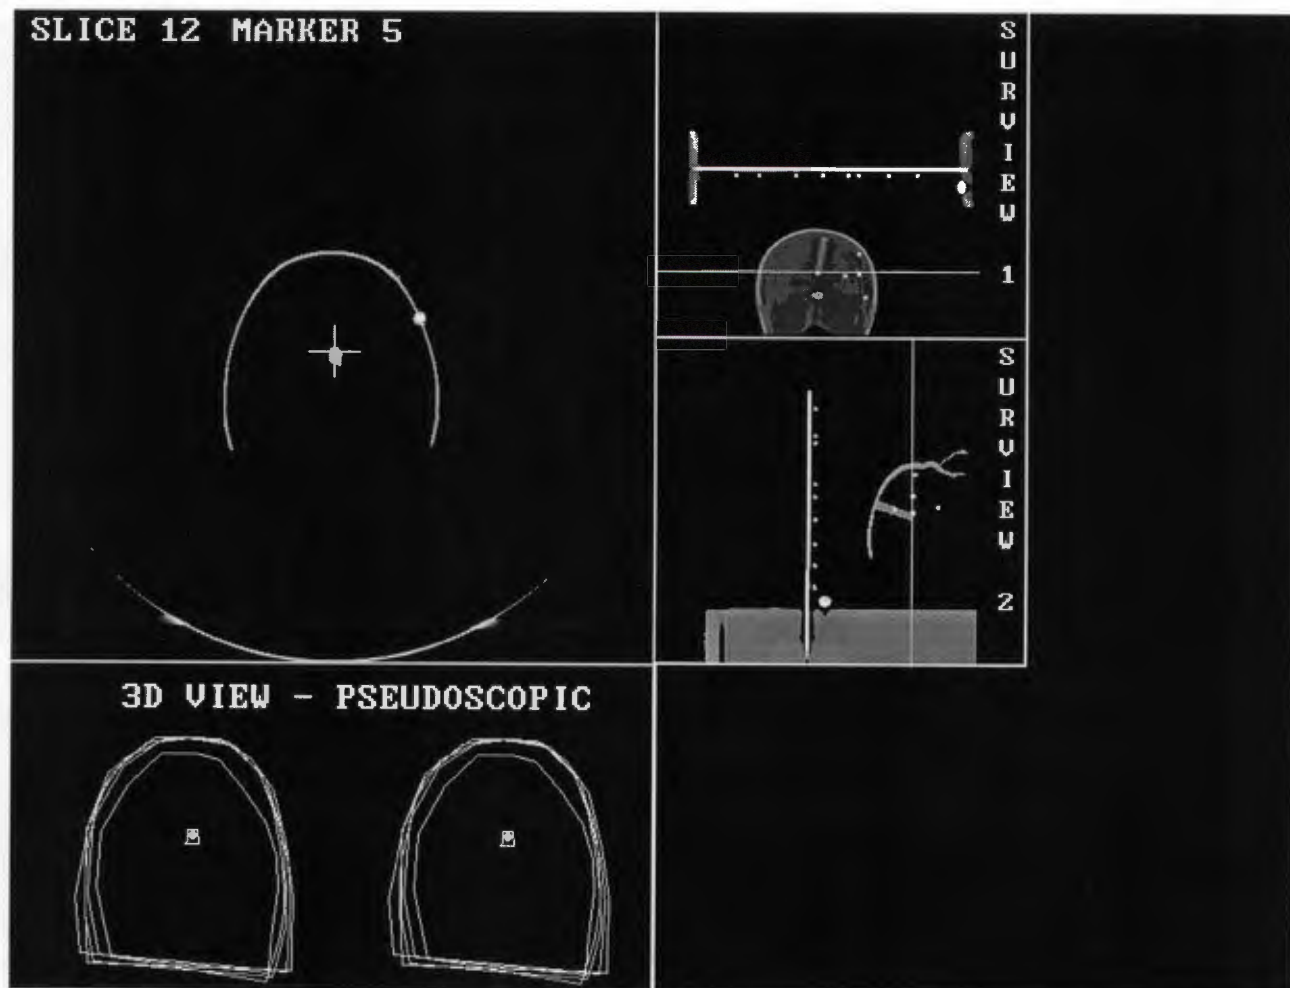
Philips screen showing CT slice through the ball-bearing representing the lesion centre
